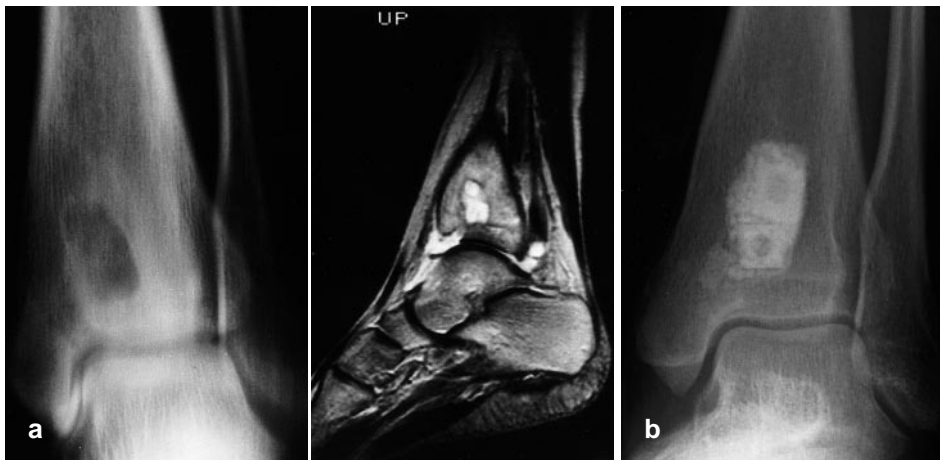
a Anterior-posterior tomoradiograph and MRI image of the distal tibia and right ankle of a 17-year-old woman with septic arthritis. b The joint and the abscess of the distal tibia were treated surgically by excision of necrotic tissue followed by insertion of CHA ceramic blocks which had been impregnated with Flomoxef sodium and Piperacillin sodium (Case 8, Table 1). Inflammatory signs around the ankle and distal tibia settled and laboratory findings were normal within eight weeks. Six years later there had been no recurrence
